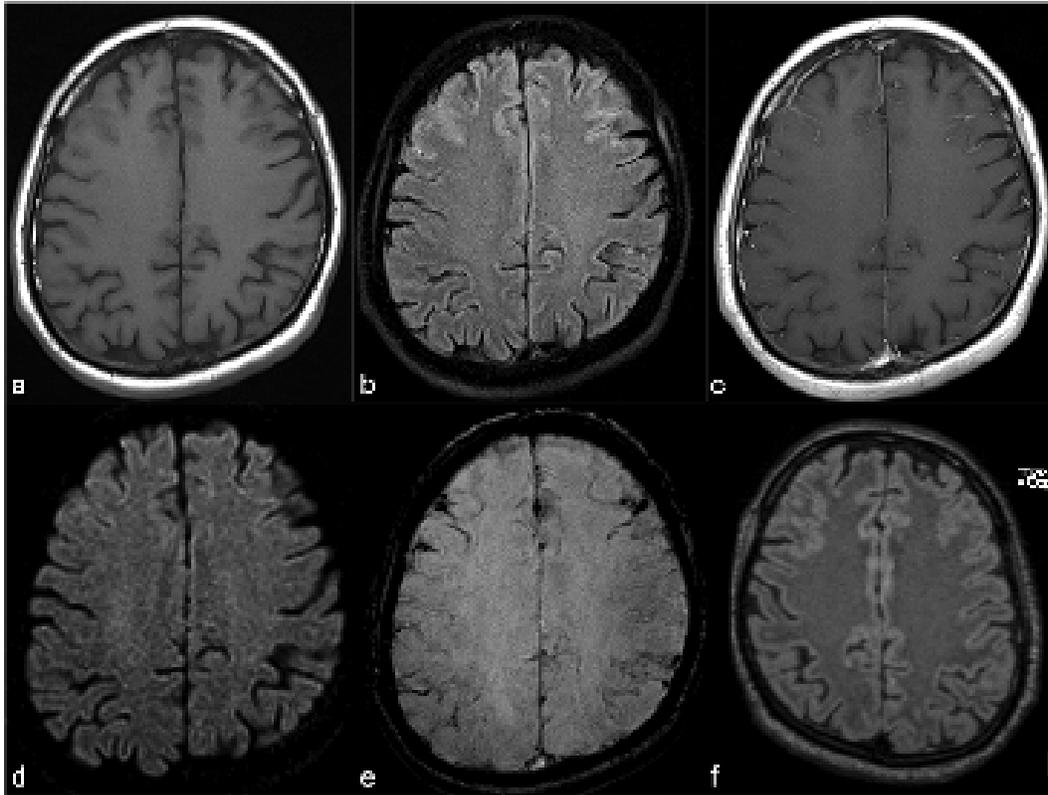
Control MRI of the 2nd patient after 7 days. Axial T1WI (a) without contrast demonstrates only mild bifrontal sulci effacement. Axial FLAIR (b) shows persistence of similar findings compared to the prior imaging. There is also stable mild cortical enhancement on post-contrast axial T1-WI (c). There is total regression of DWI (d) findings. On the contrary, SWI (e) demonstrates interval progression of the blooming artifacts. On post-contrast FLAIR (f) image, there is only mild cortical hyperintensity without enhancement.
